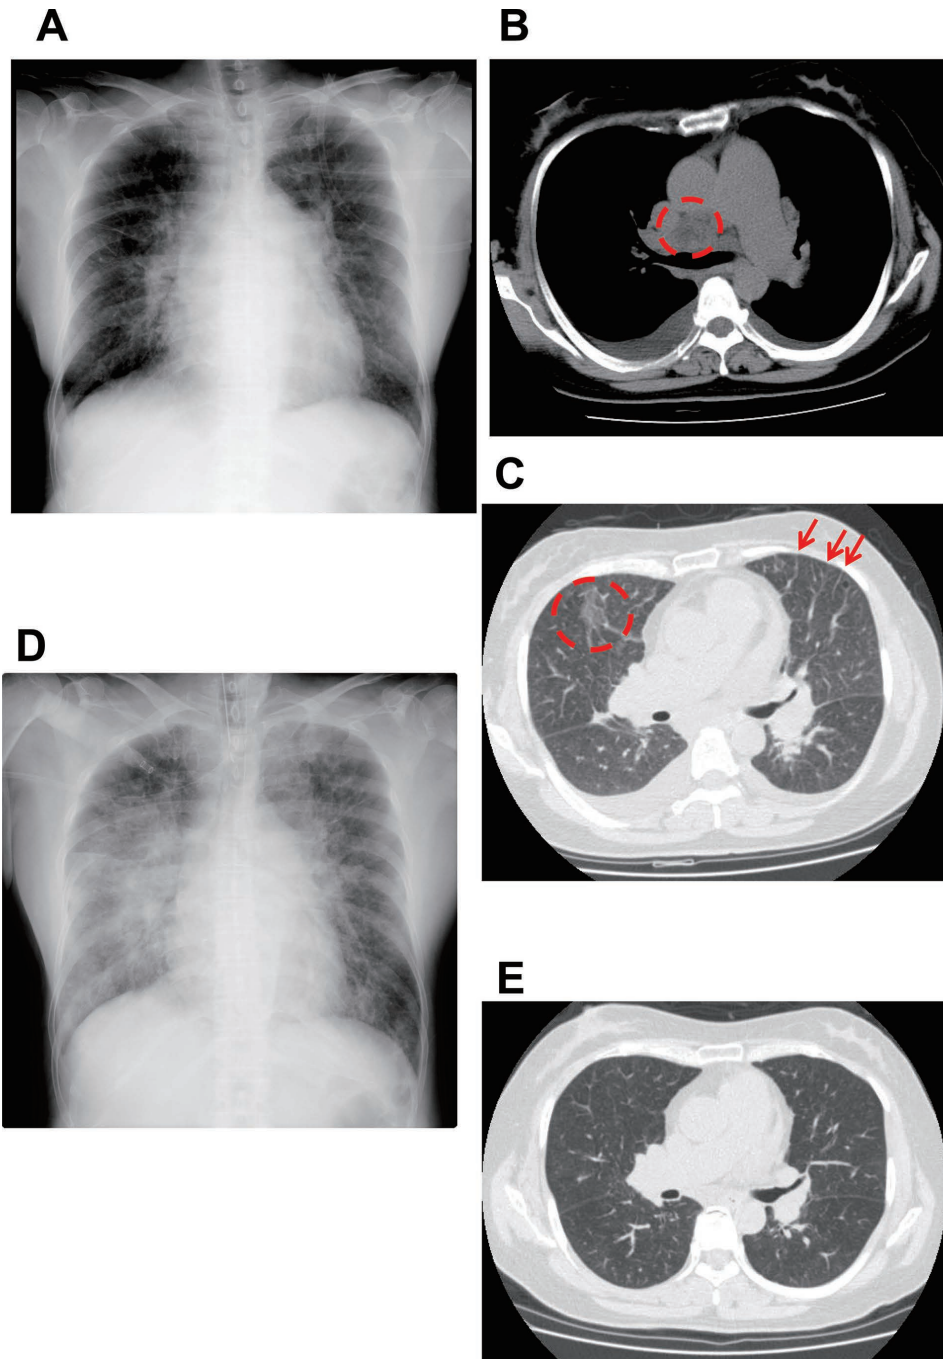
Chest X-rays and CT images.
